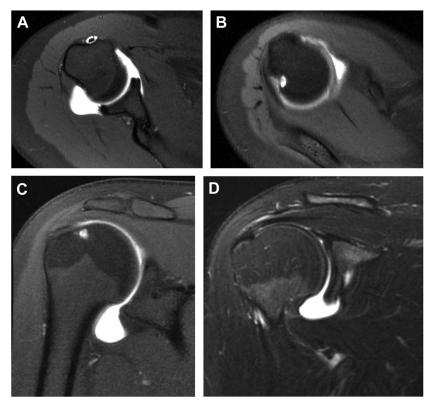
MRI arthrogram of the patient in Fig. 2, which demonstrates (A) fraying of the posterior labrum on an axial slice, as well as (B, C) a posterosuperior osseous cyst seen on the axial and coronal slices, as well as (D) degenerative tearing of the posterosuperior rotator cuff tissue.
